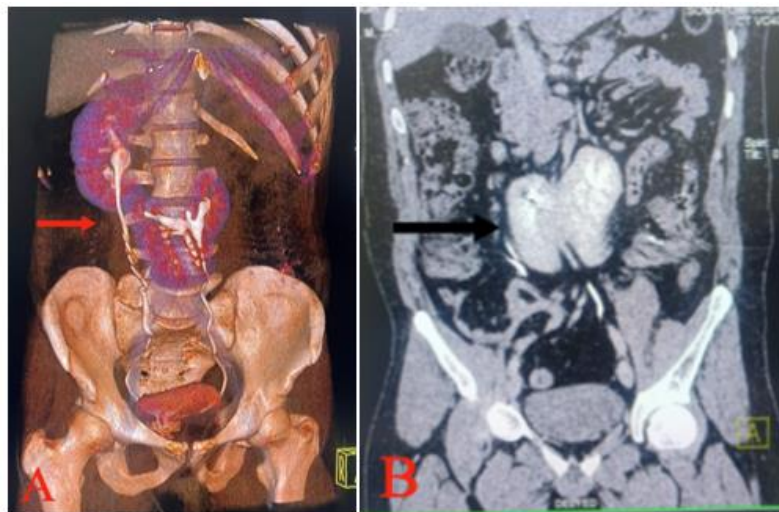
3D computed tomography (A) and CECT KUB (B) revealed left to right crossed-fused renal ectopia.
